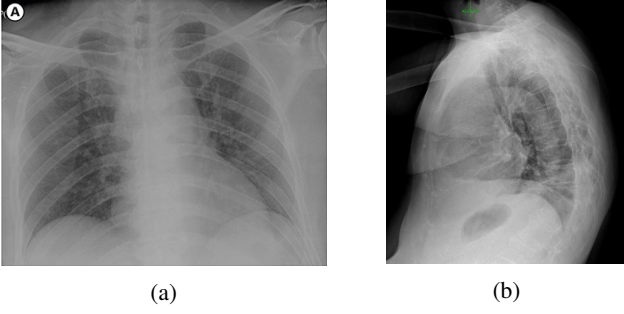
Radiograph example of images from COVID-19 image data collection [20]. (a) X-ray of a 54-year-old male, infected with COVID-19 [20]. (b) X-ray of a 70-year-old female, infected with COVID-19 [20].
